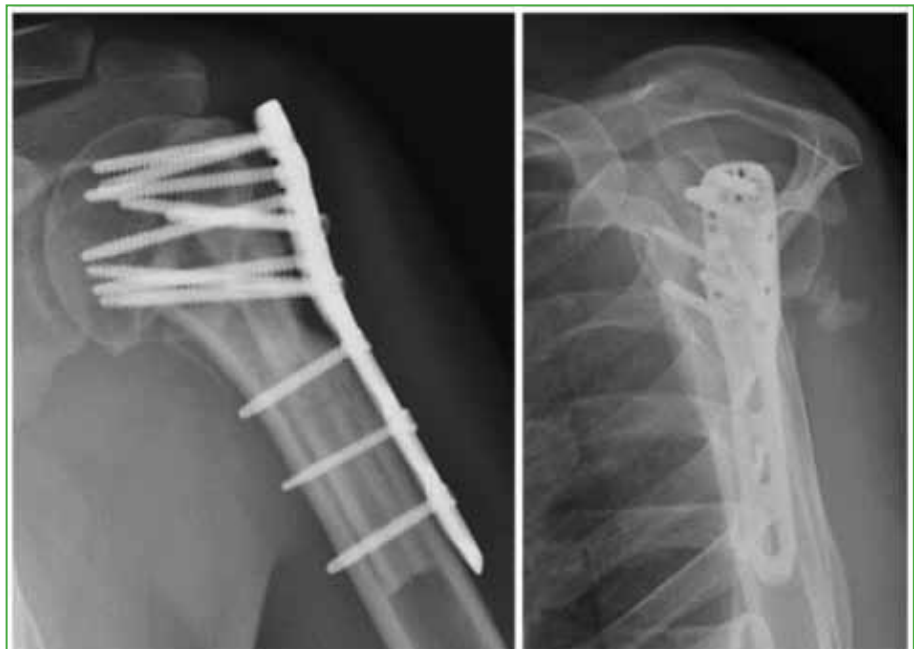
Anteroposterior left shoulder and axial scapula radiographs of the patient in Figure 2 taken in the postoperative period. Signs of fracture consolidation and the presence of endosteal strut graft are observed.
